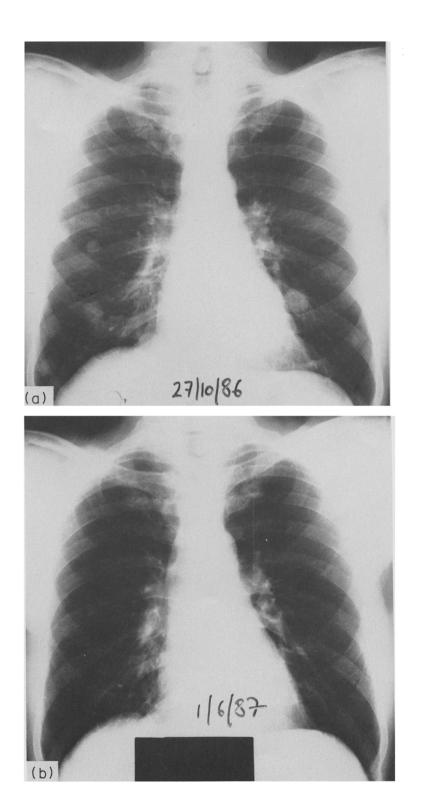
(a) Chest X-ray of patient 23, prior to carbetimer. (b) Chest X-ray of patient 23, after 7 months of treatment with carbetimer.
